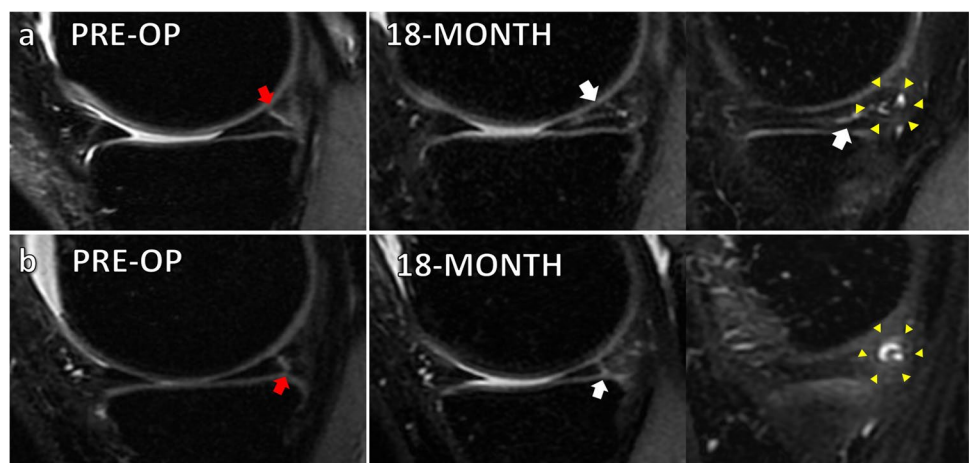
The oblique tear of the medial meniscus posterior horn and mid-body at the pre-operative status (red arrow) is not completely healed at 18-month MRI evaluation (white arrow) and a cyst is present (yellow arrowheads) (a). Another medial meniscus posterior horn tear (red arrow) is not healed after 18 months, where a hyper-intense intrameniscal signal is still present (white arrow) together with a peri-meniscal cyst (yellow arrowheads) (b)
